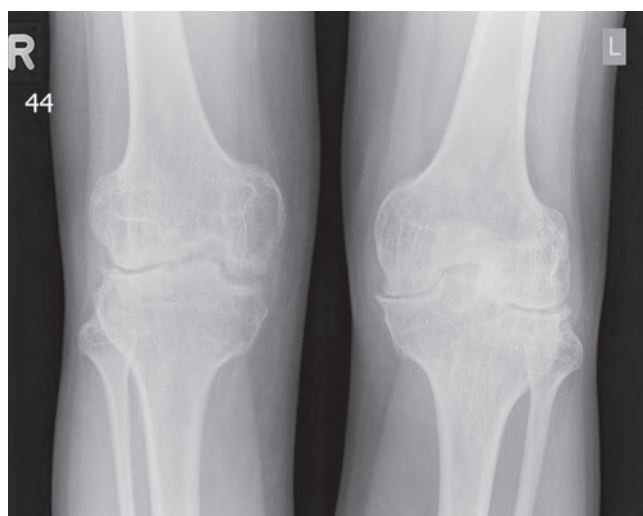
Preoperative radiographs of both knee joints in the patient with haemophilia A, showing the severe arthropathy of the left knee.
